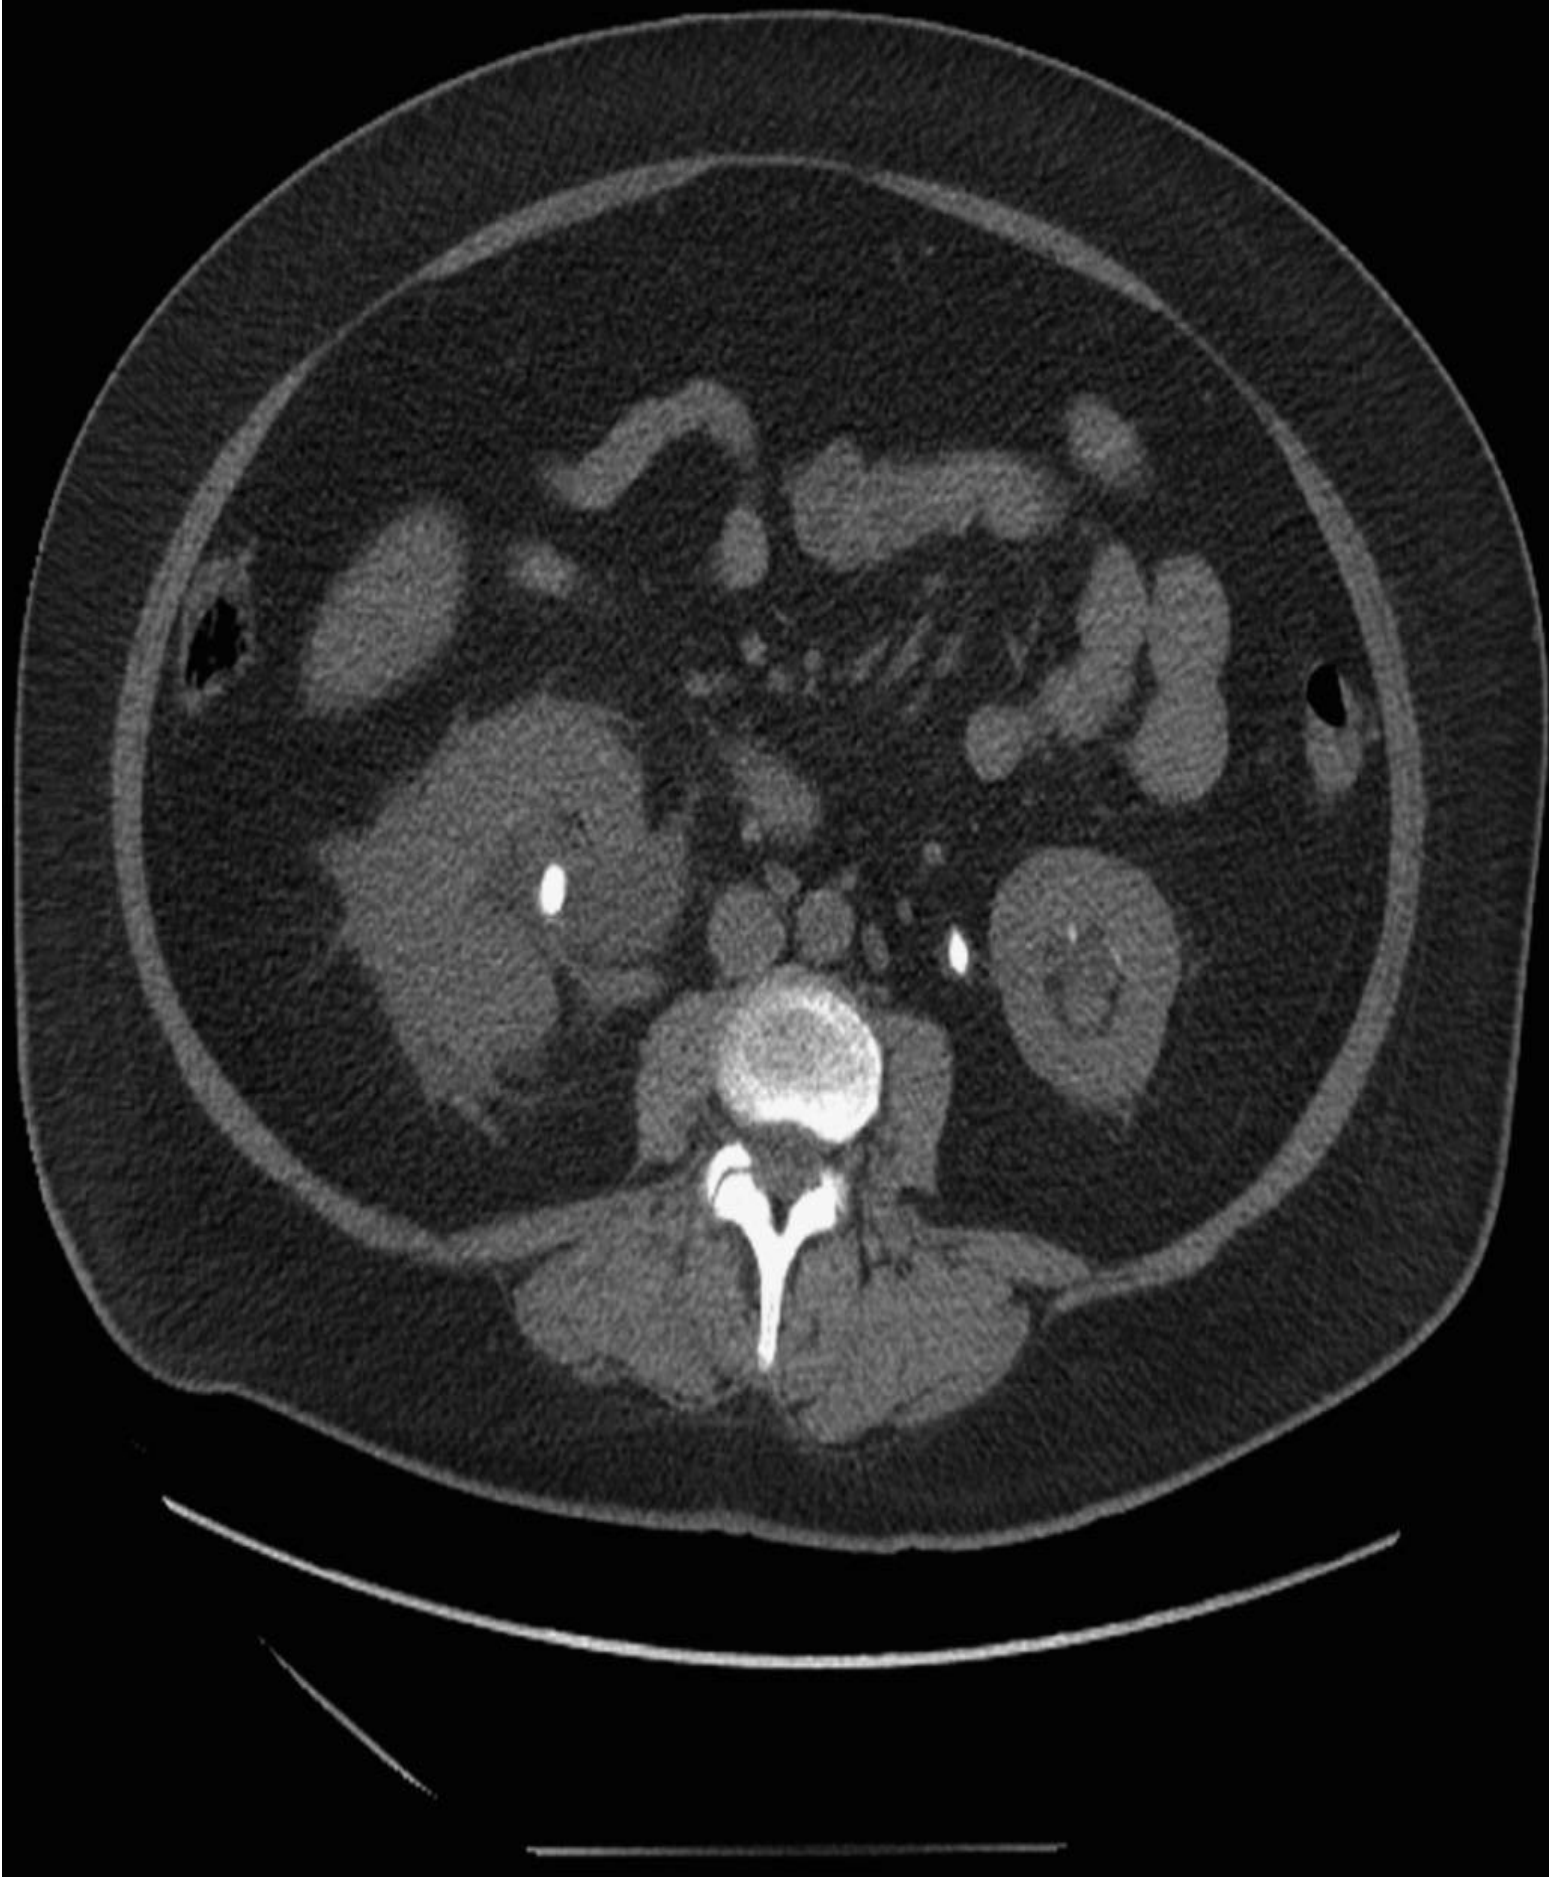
Noncontrast computed tomography scan of the abdomen and pelvis showing several stones seen (*arrowheads*). (Reproduced, with permission, from Usatine RP, et al. *The Color Atlas of Internal Medicine*. New York: McGraw-Hill; 2015.)
